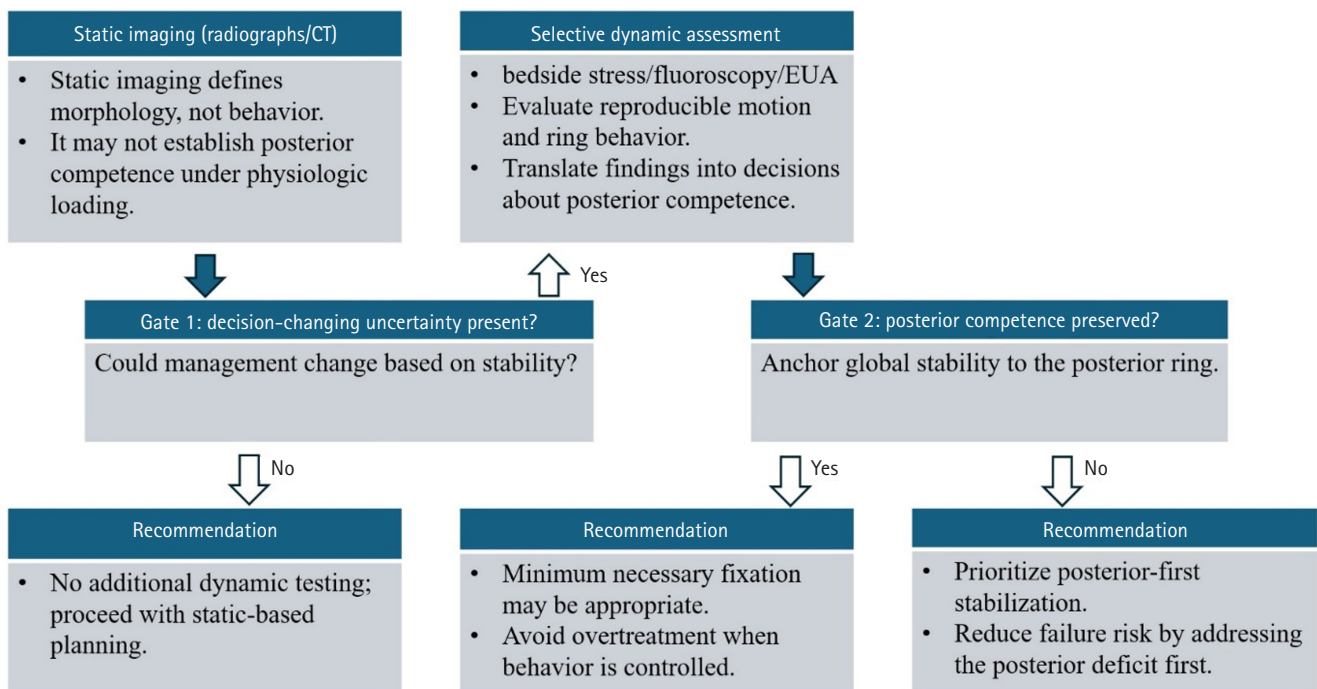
Gate-based decision framework linking static morphology to selective dynamic assessment. Static imaging using radiographs and computed tomography (CT) defines morphology and informs feasibility and operative planning, but may not reliably establish load-dependent behavior or posterior competence in borderline pelvic ring injuries. In this framework, Gates represent decision checkpoints that determine whether dynamic assessment is required and whether posterior competence should anchor management. When decision-changing uncertainty is present (Gate 1), selective dynamic assessment, such as bedside stress examination, fluoroscopy, or examination under anesthesia, documents reproducible motion and ring behavior. Posterior competence is treated as the primary anchor of global pelvic stability (Gate 2), guiding recommendations that range from static-based planning to minimum necessary fixation or posterior-first stabilization. Construct selection along the fixation continuum is summarized in Fig. 2. EUA, examination under anesthesia.
